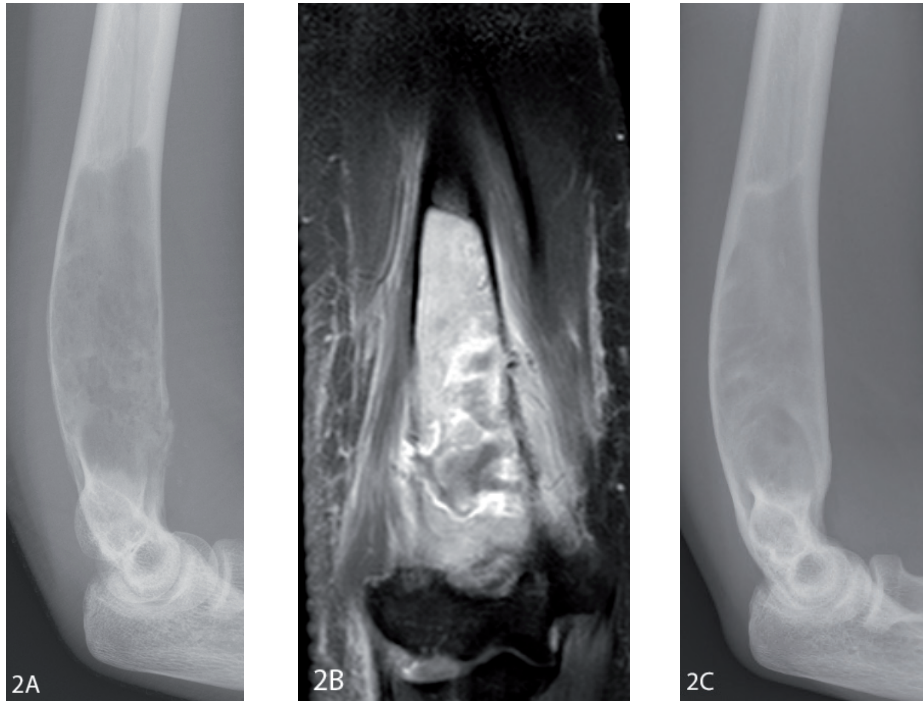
Cystic degeneration of a fibrous dysplasia lesion of the humerus. Patient nr. 8 with an osteolytic lesion in the distal part of the humerus with evident cortical thinning and a fracture on the anterior side of the humerus (2A). Formation of cysts visible in the fracture area on T1-weighted fat suppressed post-contrast MR-images, (2B). The fracture was treated with a cast resulting in good healing and no recurrent fractures. Conventional radiographs 6 years after the fracture showing increased cortical thickening and slightly increased sclerosis of the lesion compared to radiographs at diagnosis (2C).
